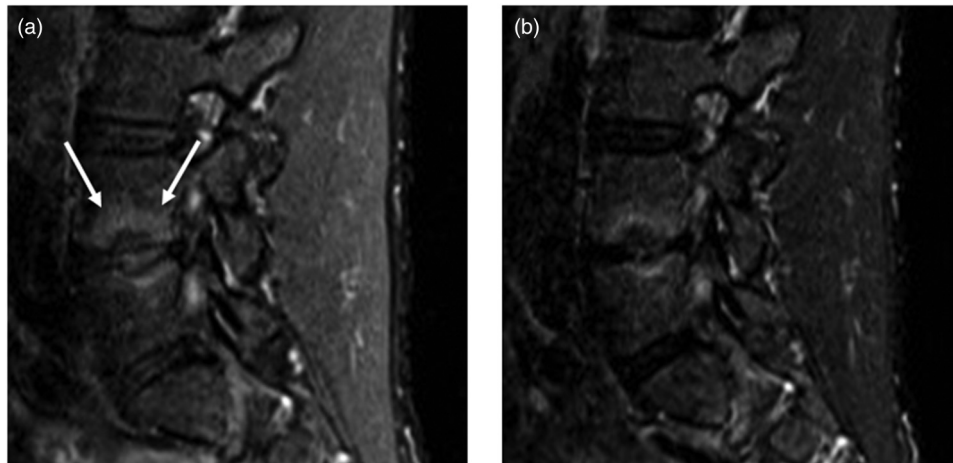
Difference in fat suppression between DixonT2w and STIR. (a, b) A 31-year-old man with chronic low back pain. More uniform suppression of subcutaneous fat on (a) DixonT2w compared to (b) STIR. DixonT2w, T2-weighted Dixon water images; STIR, short tau inversion recovery.
